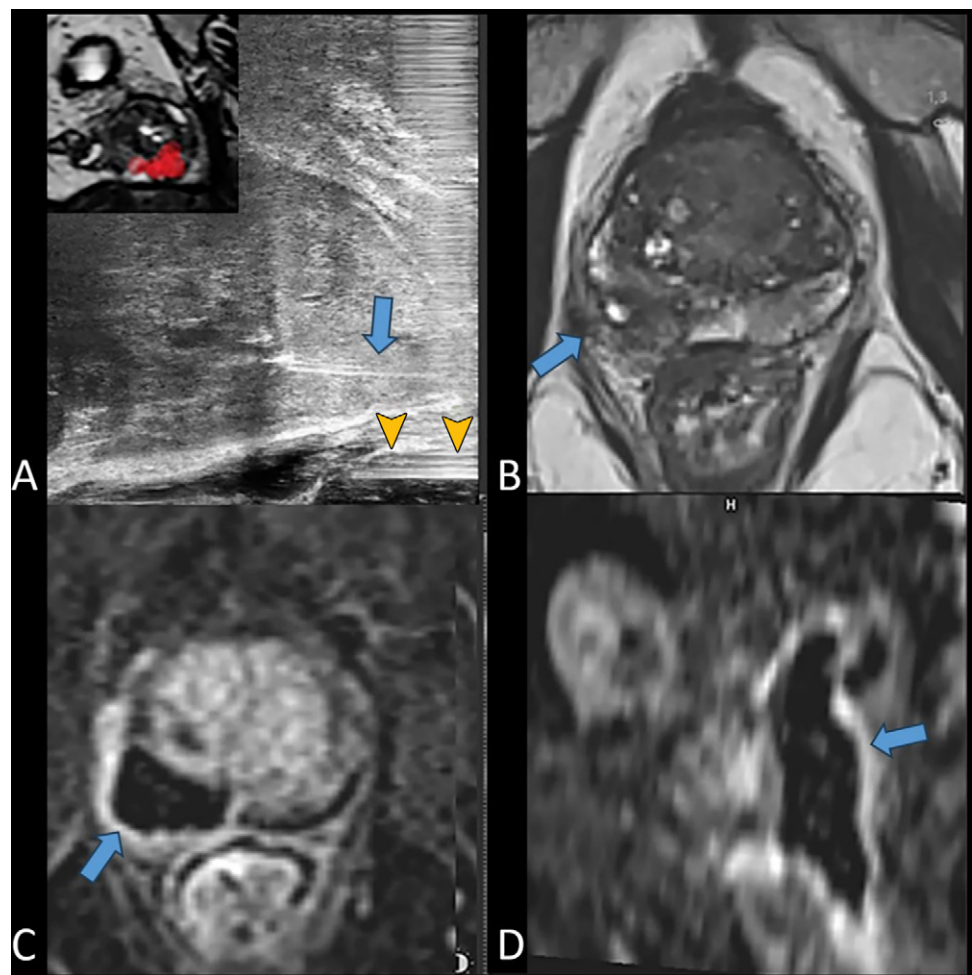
Treatment and follow-up images in a 74-year-old male participant (also in Fig 2). (A) Longitudinal micro-US image. The participant underwent rectoprostatic hydrodissection before focal laser ablation (FLA). A 21-gauge needle (arrow) was placed in the medial part of the lesion, which abuts the rectal wall. The needle inserted into the rectoprostatic space for hydrodissection (arrowheads) is used to inject hypertonic glucose serum to detach the prostate from the anterior surface of the rectum. The inset on the upper left quadrant of A shows the MRI scan fusion, with red tags delineating the boundaries of the target volume. (B) Three-dimensional transverse T2-weighted image obtained 4 days after FLA shows that the area of the lesion has a low-intensity signal (arrow). Fluid is visible centrally within the lesion. (C, D) Axial and sagittal dynamic contrast-enhanced images show that the ablation volume is avascular (arrow). The rectal wall, which is in contact with the medial part of the tumor, has a normal appearance. Note the basal and cranial extension of the ablation zone (D), which provides an oncologic safety margin.
